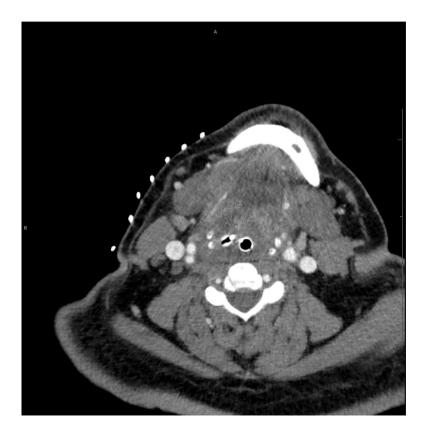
Axial CT of head and neck with contrast, prior to procedure on hospital day 3. Abscess phlegmon measuring 2.21 cm x 1.32 cm.
